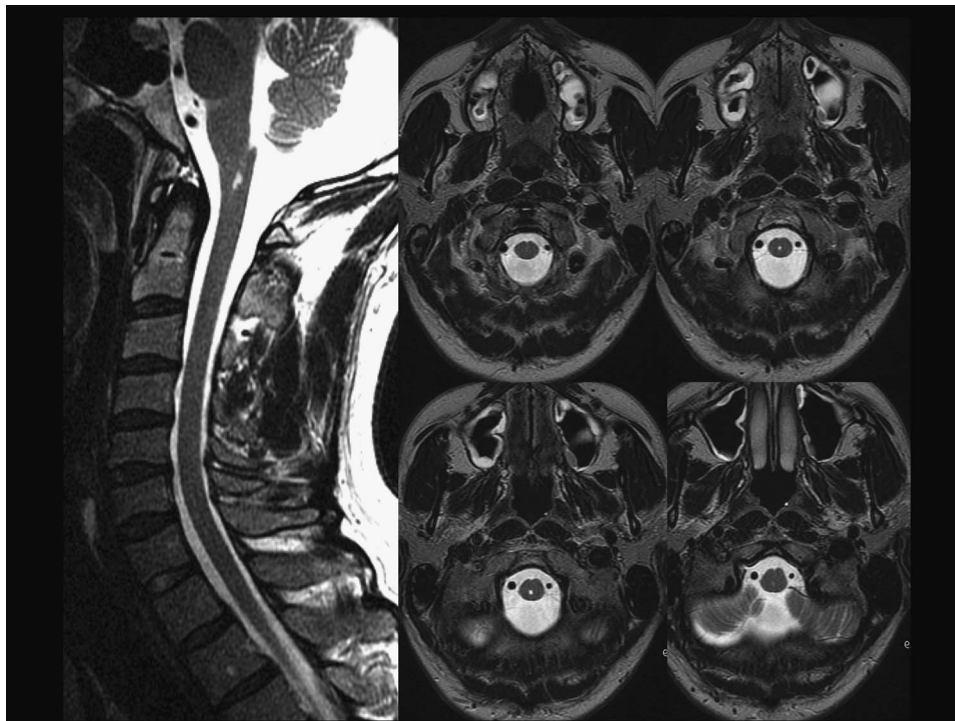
Sagittal and axial T2 weighted MR images demonstrating a medullary syrinx.
